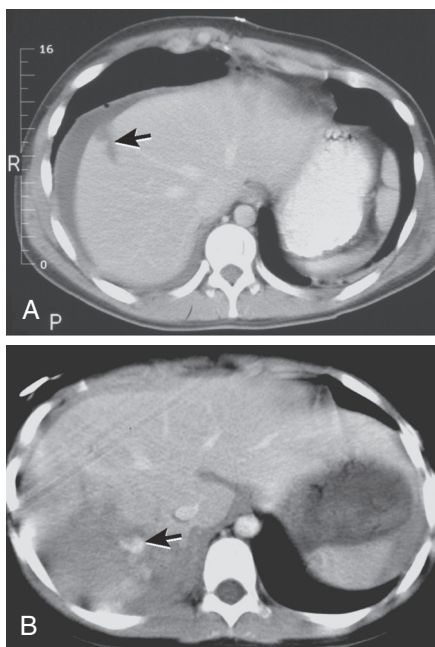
Small and large hepatic lacerations. A, A computed tomography (CT) scan was obtained through the upper abdomen in this patient after a motor vehicle accident. A small area of low density (*arrow*) is seen in the lateral portion of the right lobe, and blood surrounds the liver. B, A CT scan in another patient after a motor vehicle accident shows a much larger area of lacerated liver in the posterior aspect of the right lobe. A central area of increased density (the white area at the *tip of the arrow*) indicates acute hemorrhaging at the time of the scan. (From Mettler F. *Essentials of radiology*. 2nd ed. Philadelphia: Saunders, 2004, Fig. 6-47.)
